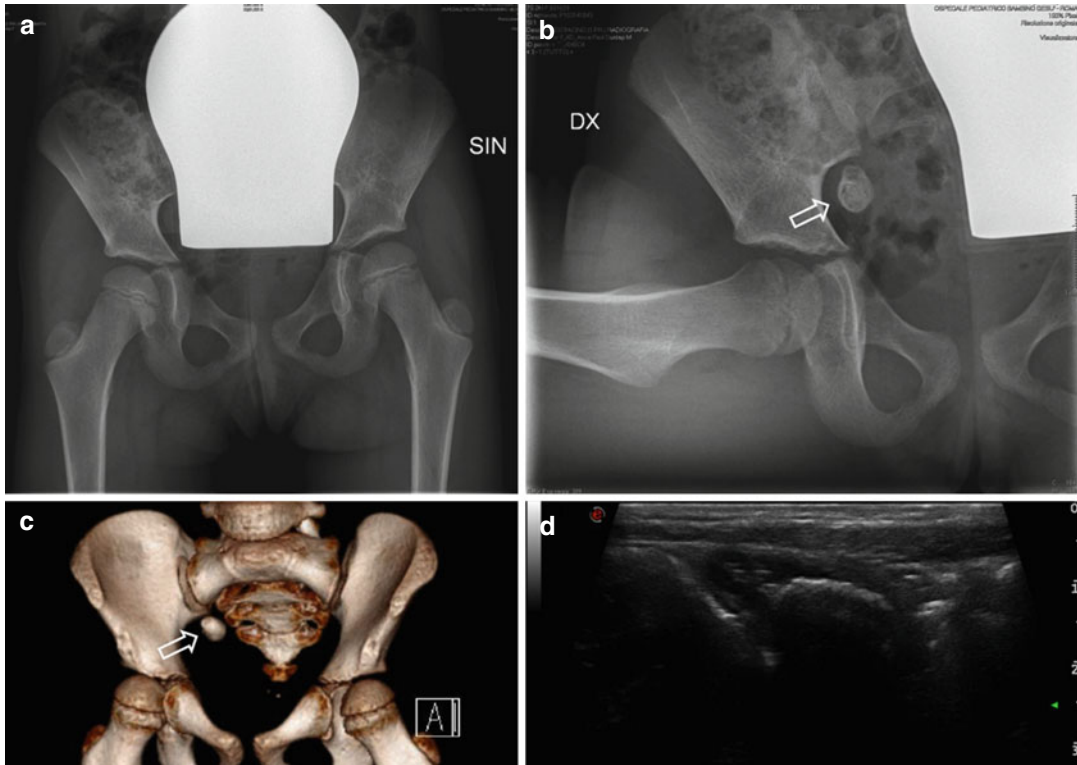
Limping child. The AP pelvis x-ray (a) does not show significant findings, while in the axial projection (b), a gross calcification into the pelvis (previously masked
